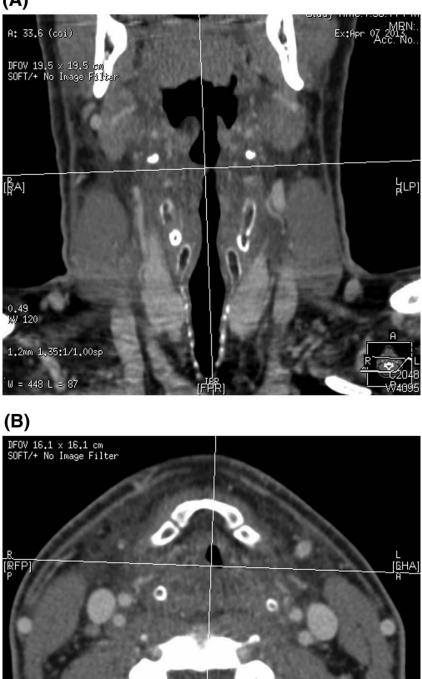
(A) Coronal computed tomography image of the neck showing extensive laryngeal and supraglottic edema associated with narrowing of the airway, extending from the level of the cricoid cartilage to the epiglottis. (B) Axial computed tomography image of the neck showing extensive laryngeal and supraglottic edema associated with narrowing of the airway, extending from the level of the cricoid cartilage to the epiglottis.
